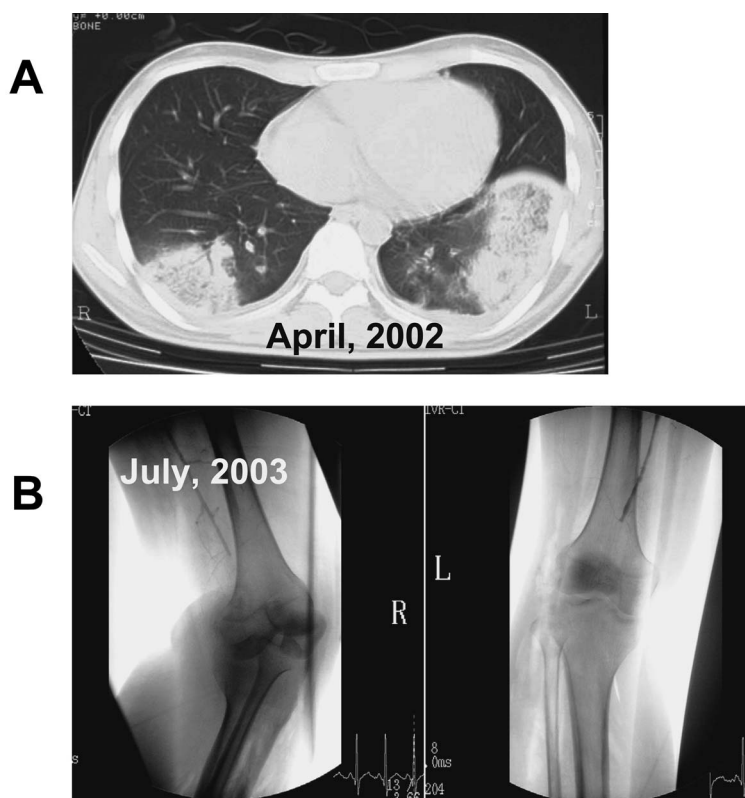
(A) Chest CT scan of the patient demonstrates the air-space consolidation of bilateral lower lobes in April 2002. (B) Angiogram shows complete obstruction of bilateral brachial arteries of the same patient in July 2003.
